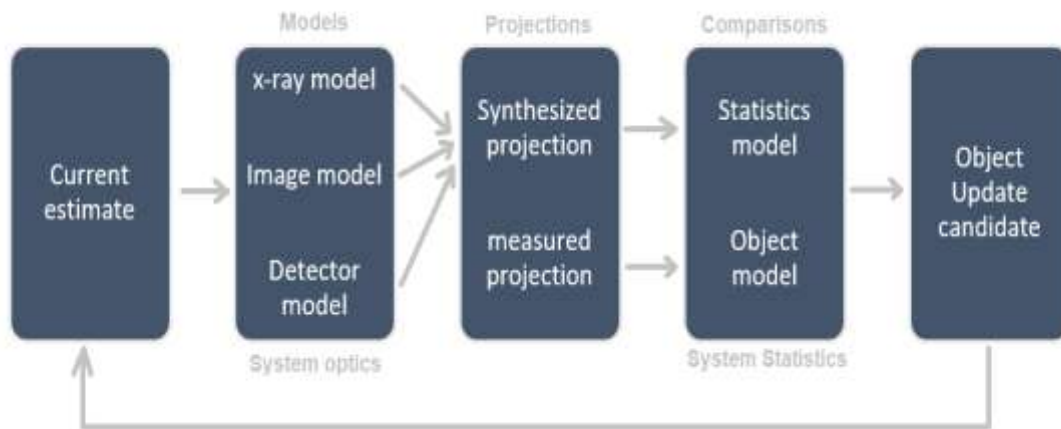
An MBIR inputs and data flow. The system optics includes a number of inputs from the X-ray characteristics (such as focusing spot), the image data (such as anatomy and geometry), and the detector (such as sampling). [24]
